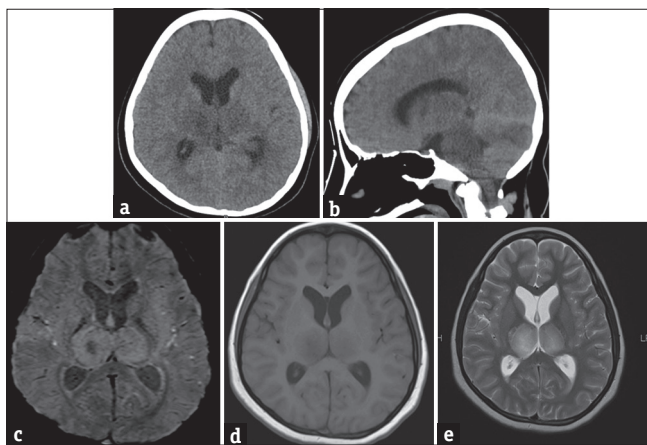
Computed tomography and magnetic resonance imaging of the patient. (a) Computed tomography scan brain showing diffuse low attenuation areas in pons with effacement of the lateral ventricle. (b) Computed tomography scan brain showing diffuse low attenuation areas in pons with gradual transition to midbrain and medulla. (c) Abnormal, symmetrical signals in the thalamus and midbrain. (d) Lesions are appearing hypointense on T1-weighted images. (e) Hyperintense on T2-weighted images and showing minimal postcontrast enhancement. Necrotic areas are also identified in the right thalamus and both sides of the pons which are showing peripheral enhancement
